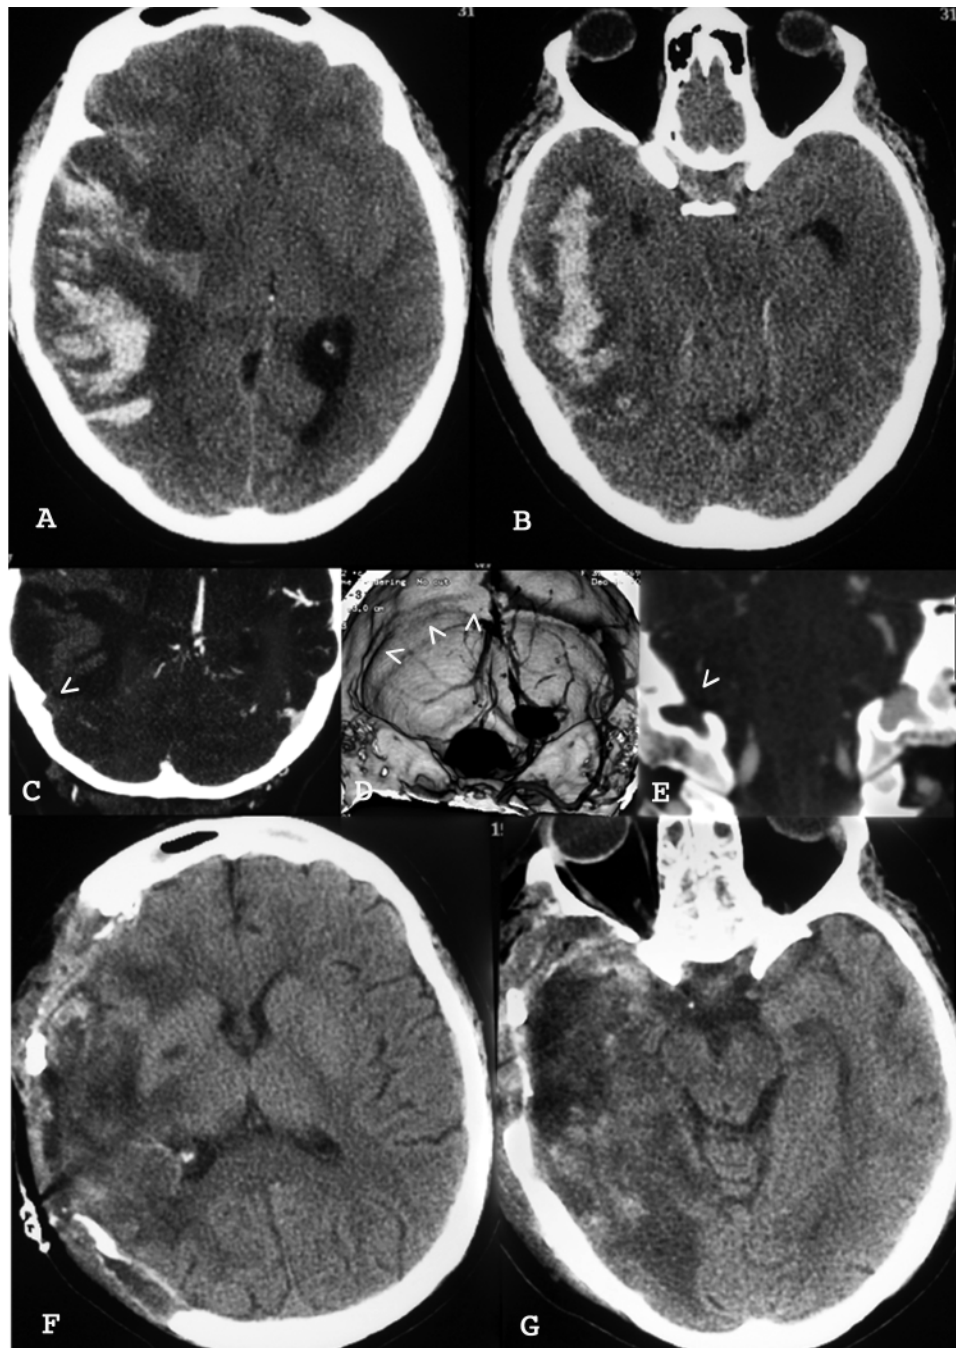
Case 1. A and B: Preoperative CT revealing a hemorrhagic infarction of the right temporal lobe with midline shift and transtentorial herniation brainstem compression. C and D: Preoperative CT angiograms demonstrating the non-opacification of the transverse sinus on the right side. The *arrowheads* indicate the transverse sinus sulcus. E: Preoperative CT angiogram in frontal projection showing the non-opacification of the jugular bulb on the right side; the jugular foramina are symmetrical. The *arrowheads* indicate the jugular foramen. F and G: Postoperative CT obtained after the second operation.
